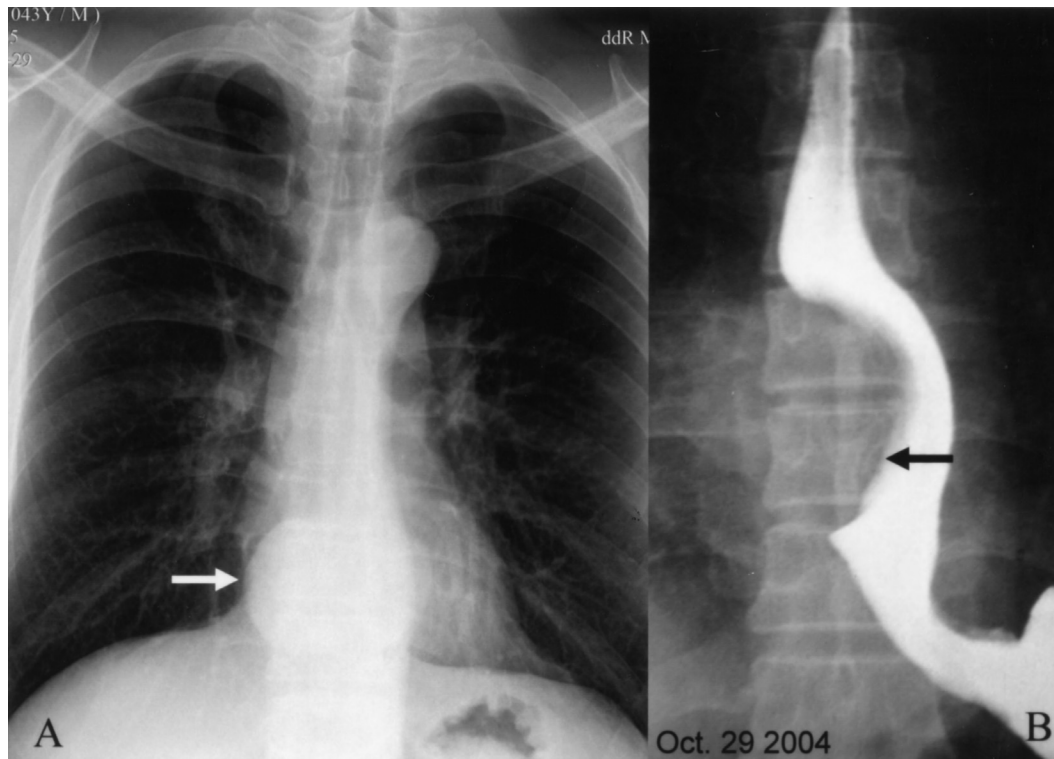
Preoperative image study of patient 2. A. Chest radiography shows a round-shaped tumor (arrow) at the retrocardiac region. B. Esophagography reveals marked esophageal indentation due to external compression (arrow).
